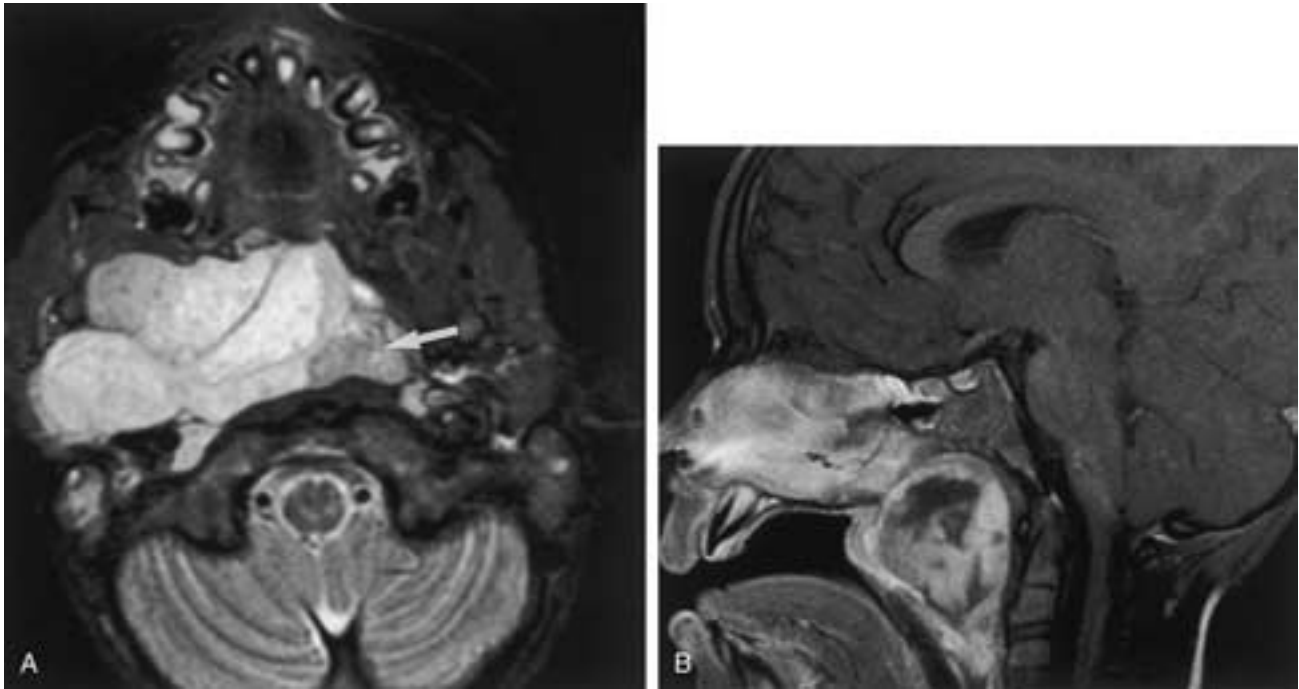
RMS of the pharynx in a 6-year-old boy with a 1-month history of nasal congestion, nasal voice, and noisy snoring. A, Axial FSEIR image reveals a large tumor involving the adenoids, extending anteriorly into the airway and laterally toward the muscles of mastication (*arrow*). B, Sagittal T1-weighted image reveals the heterogeneously enhancing tumor partially obstructing the nasopharynx.
